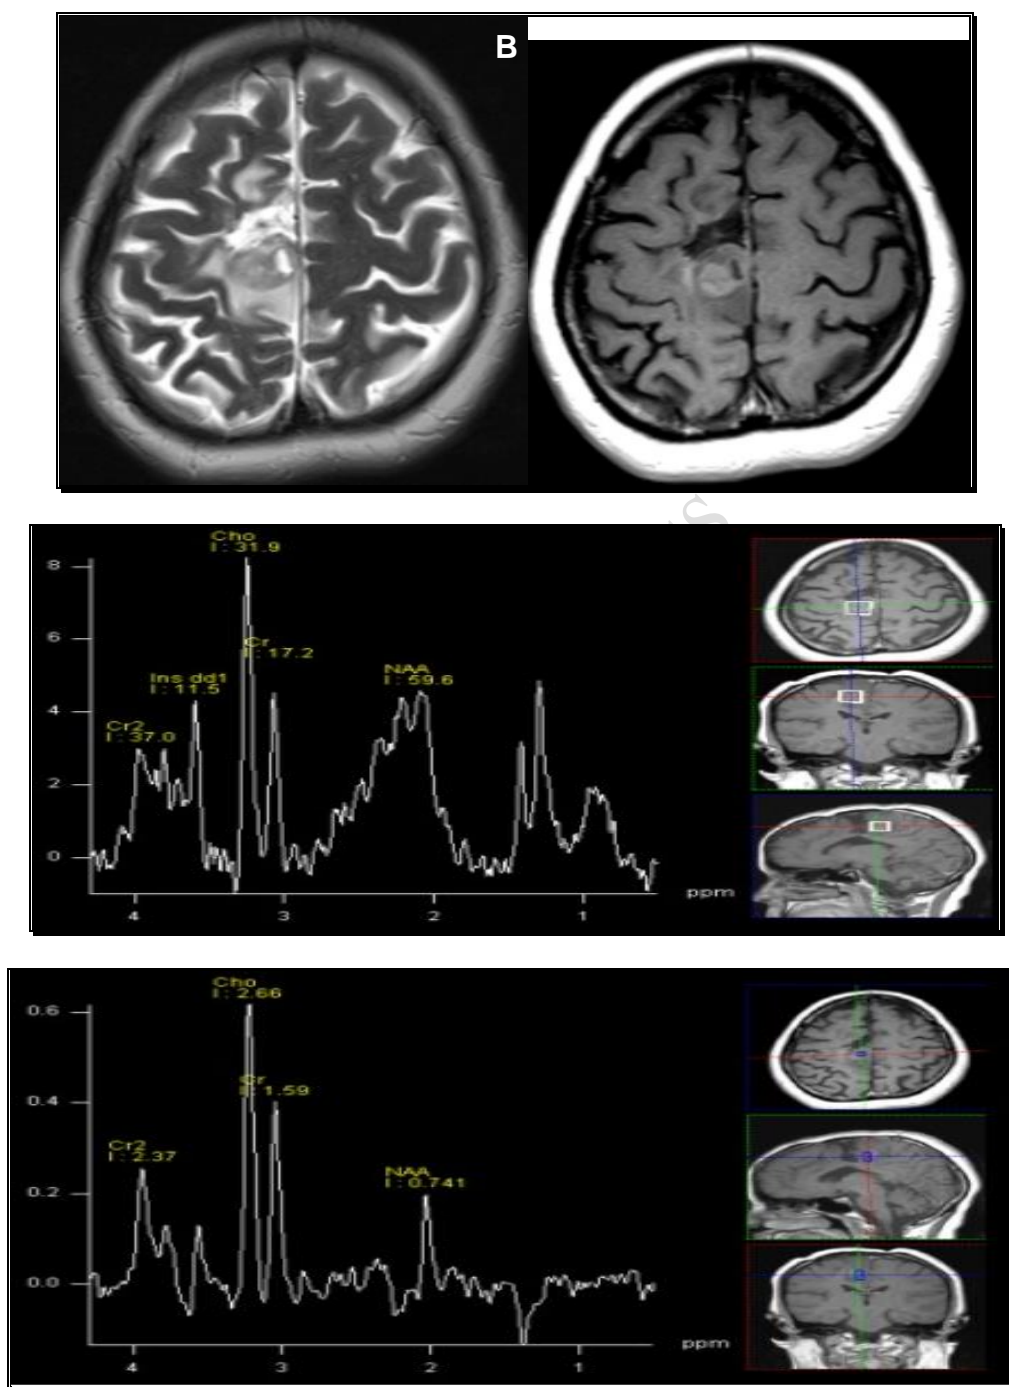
Recurrent tumor. Follow-up MRI and MRS study after receiving resection and radiotherapy for right cerebral grade IV glioblastoma. Axial T2 weighted image (A) showing right high frontal abnormal mixed hypointense and hyperintense signal with mild perilesional edema. Post-contrast axial T1 weighted image (B) showing small enhancing space occupying lesion. MRS with short (C) and long TE (D) with the volume placed over the enhancing lesion showing significantly elevated choline peak, with decreased NAA and Cr peaks, and prominent lipid and lactate peaks. There is elevated Cho/NAA ratio (3.56) and Cho/Cr ratio (3.2).
